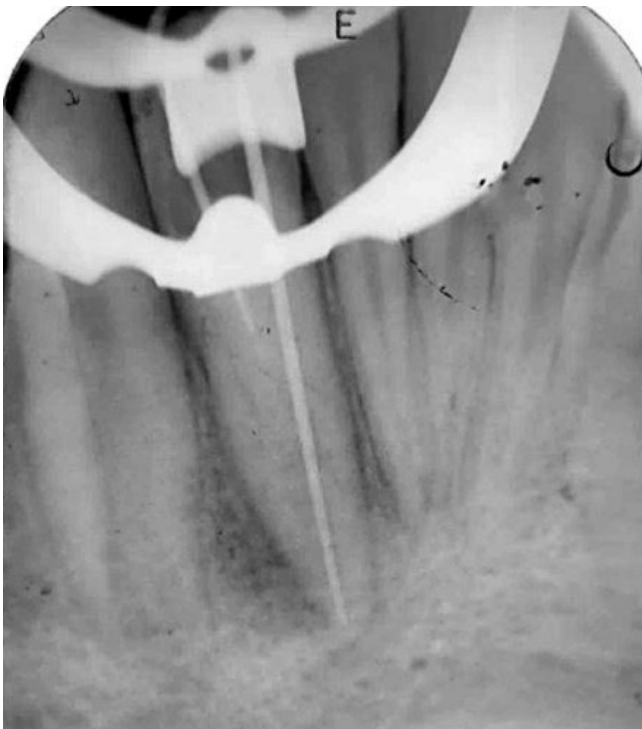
Master cone radiograph demonstrating proper fit of size #60 gutta-percha cone within the root canal space before obturation.
